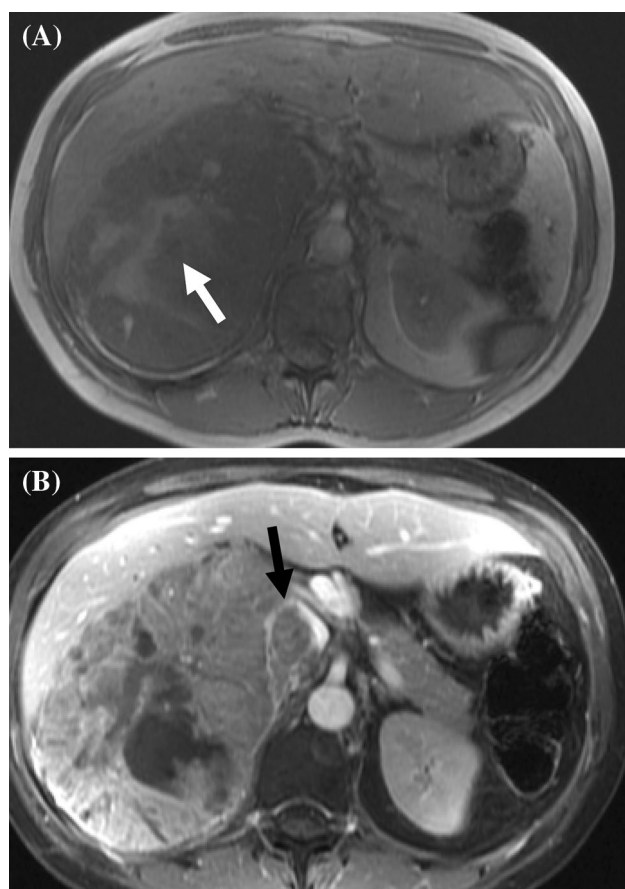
A 31-year-old with ACC. a Axial T1-weighted MR image shows a large right suprarenal mass with hemorrhagic component (white arrow). b Axial T1 post-contrast MR image shows the large heterogeneously enhancing right adrenal mass invading the inferior vena cava (black arrow)
